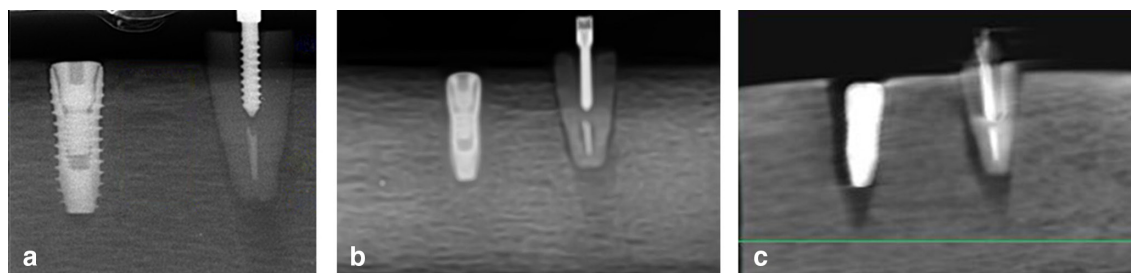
Different radiographical modalities of a bone block with an implant and a root having an intracanal post: (A) periapical view, (B) panoramic view, (C) CBCT.
